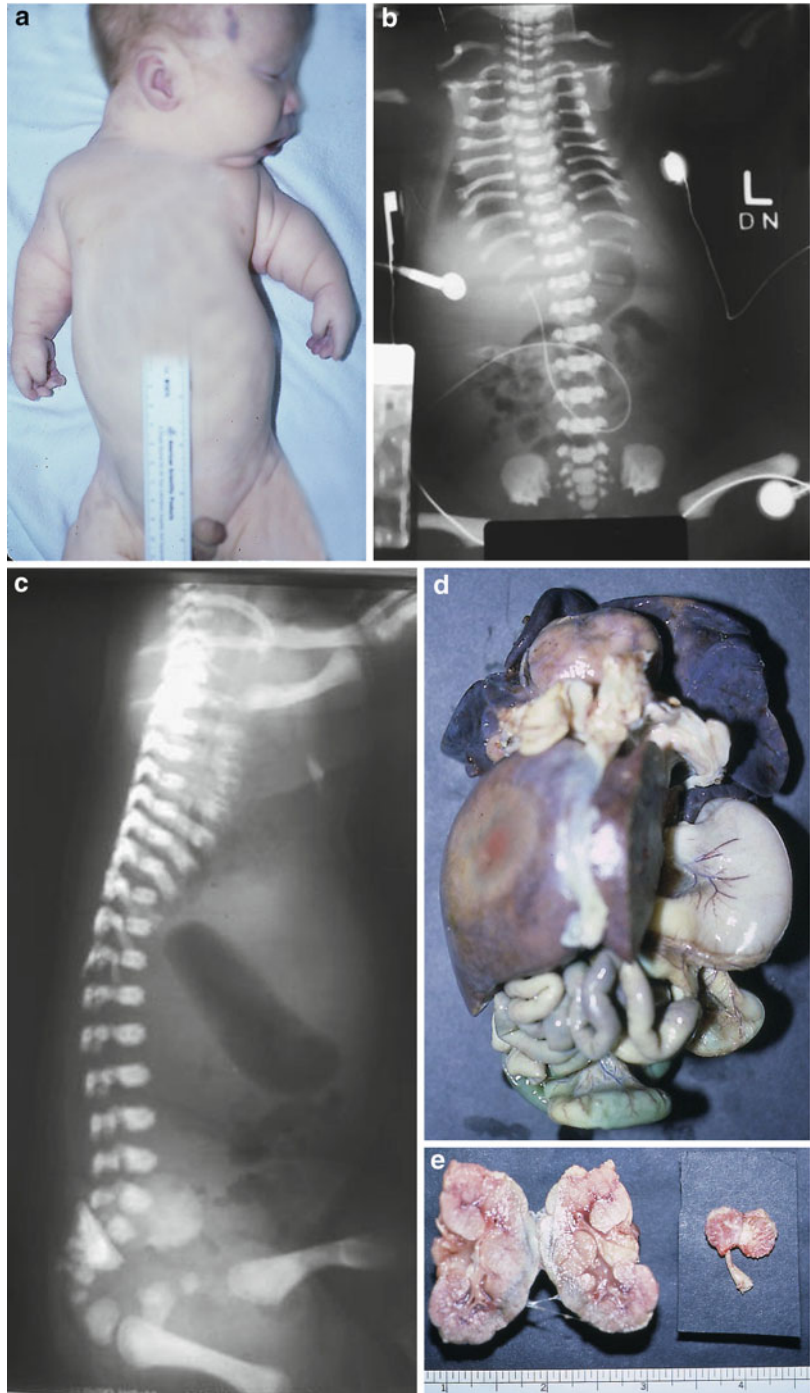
(a–e) An infant with type II asphyxiating thoracic dystrophy showing a narrow thorax and short *upper* extremities. The radiographs showed the handlebar clavicles, short horizontal ribs with widened/cupped anterior rib ends, and *square-shaped* iliac bones with the medial spurs of both acetabular roofs. The necropsy showed lung hypoplasia and renal cystic dysplasia and hypoplasia
